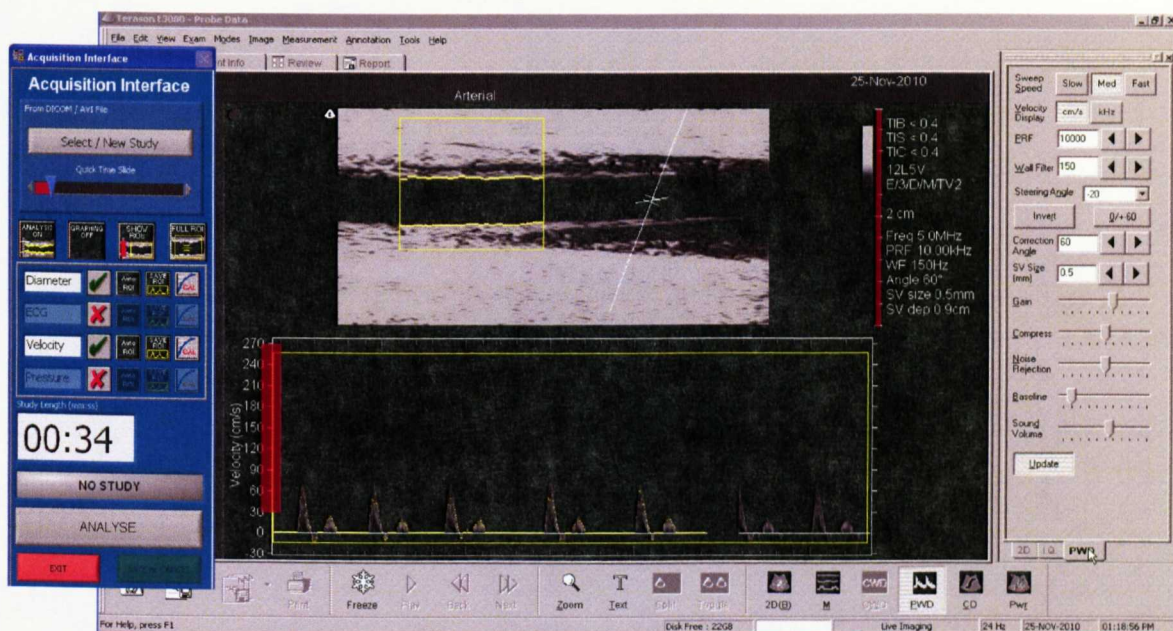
2D B-Mode Ultrasound image recording of the brachial artery diameter and velocity in the analysis software with regions of interest (ROI) highlighted in yellow.
